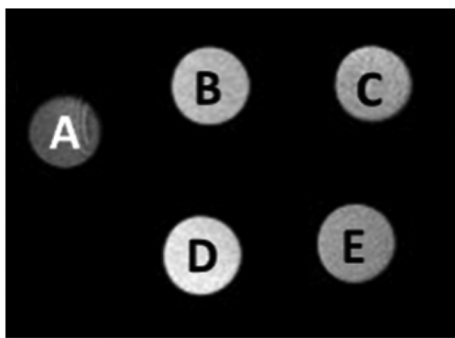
T_1 -Weighted MRI images of selected LGdH-drug intercalates. Images are shown for (A) a 1% w/v agarose gel (negative control); suspensions of LGdH-ibu with Gd concentrations of (B) 0.5 and (C) 0.25 mM; and, suspensions of LGdH-dic at Gd concentrations of (D) 0.5 and (E) 0.25 mM.
